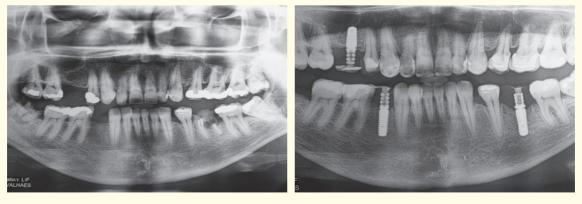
Panoramic radiograph at the beginning of the treatment and after the completion of the first step of the work.
